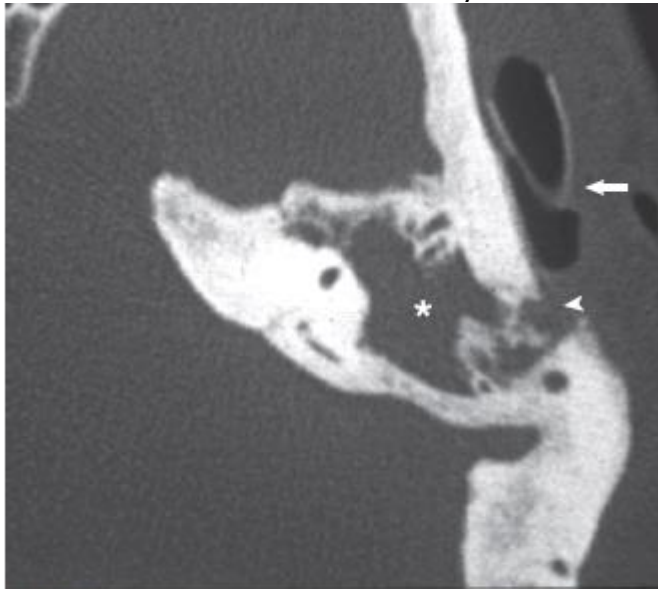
Axial temporal bone computed tomography scan (soft tissue) shows abscess cavity with gas (arrow). Note cortical defect (arrow-head), mastoid opacification, and loss of bony septa (asterisk).
